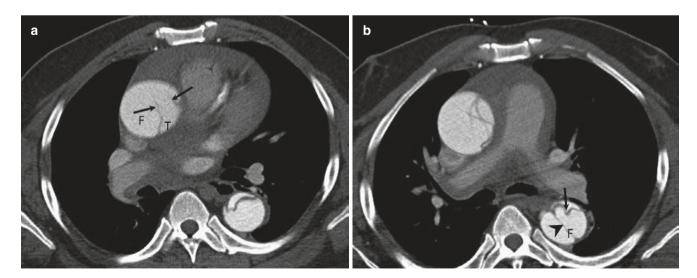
"Intimomedial rupture" sign, "cobweb" sign, and pericardial effusion in type A dissection. (a) Axial CT aortogram shows intimomedial entrance tear (arrows) opening toward the false lumen. (b, c)
